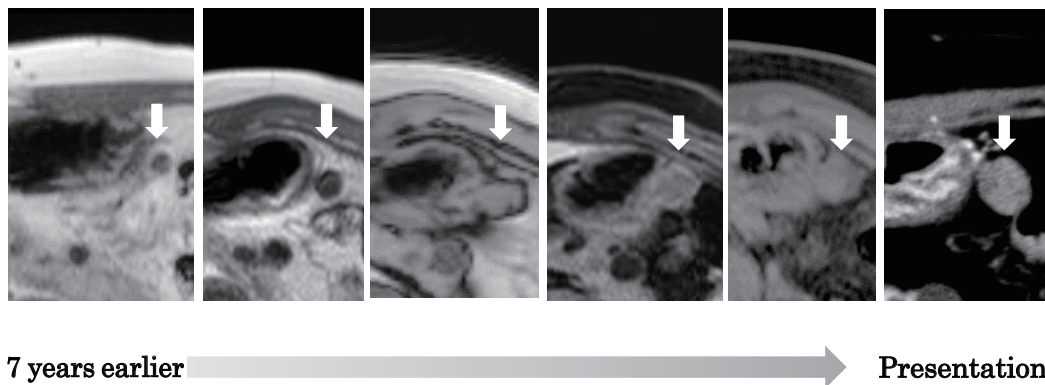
Serial images of low-risk exophytic GIST (arrow) over 7 years. From the left side, T1WI MRI at 7, 4, and 3 years earlier; enhanced MRI at 2 years earlier; T2WI MRI at 1 year earlier and enhanced CT at presentation. CT, computed tomography; GIST, gastrointestinal stromal tumor; MRI, magnetic resonance imaging.
